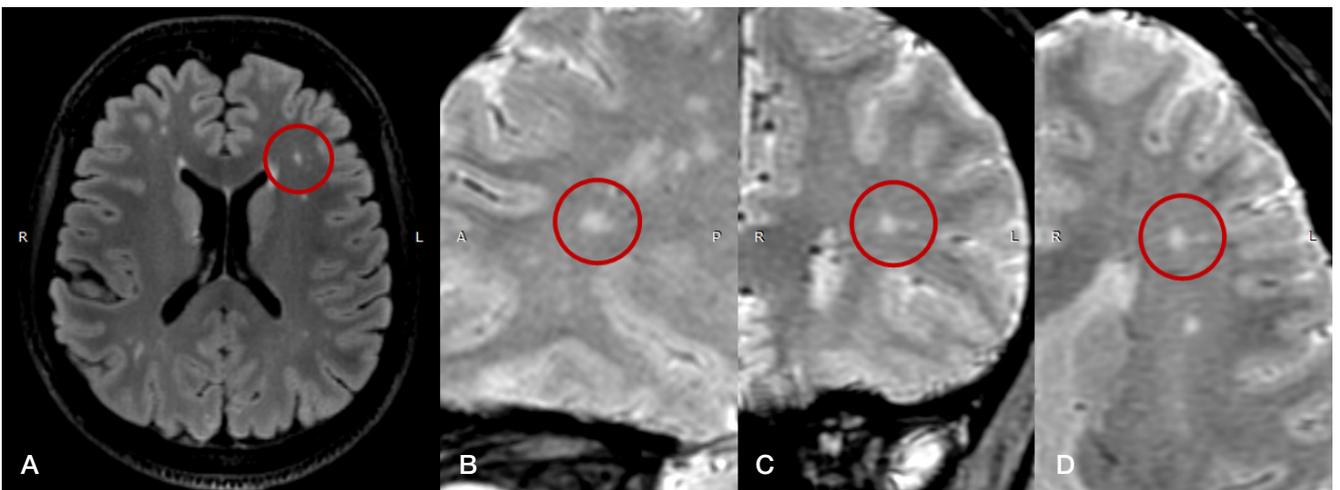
Magnetic resonance images of patient 2. A. A T2-weighted fluid-attenuated inversion recovery (FLAIR) image, the axial plane. The image shows a round lesion in the deep white matter of the left frontal lobe (marked by the red oval). B. A susceptibility-weighted (SW) image, the axial plane. The image shows the same lesion, the central vein sign is not visualized (the red oval). C. A susceptibility-weighted (SW) image, the sagittal plane. The same lesion, the central vein sign is not visualized; a smaller lesion not suitable for the analysis is located in close proximity (the red oval). D. A susceptibility-weighted (SW) image, the coronal plane. The same lesion, the central vein sign is not visualized (the red oval)
